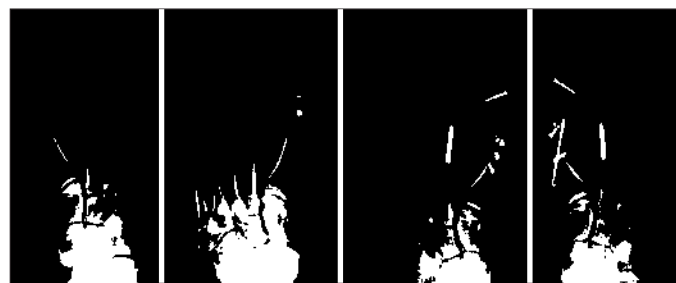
Pre- and postoperative X-rays showing bilateral hallux valgus correction and shortening osteotomy of the second ray with K-wire fixation.
